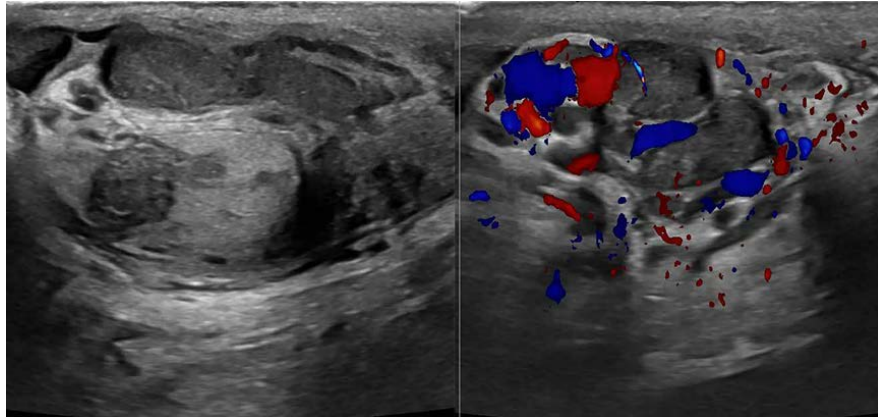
Ultrasound image of the patient's left scrotum. The epididymis is bulky with an abnormal heterogenous hypoechoic appearance, and with increased vascularity.
